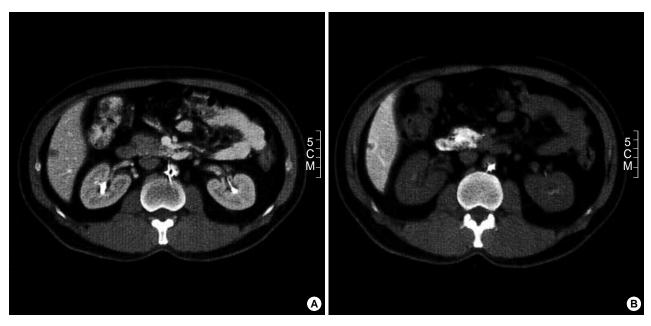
Abdominal computed tomography. Aortoportogram phase (CTAP) shows a well-demarcated nodule with homogeneous low density (A). Hepatic arterial phase (CTHA) shows round nodule with peripheral enhancement (B).
